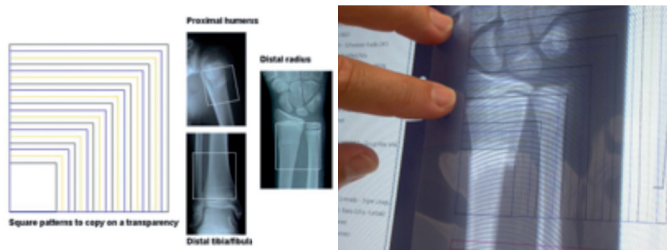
Use of the square patterns to classify a fracture as epiphyseal (E), metaphyseal (M) or diaphyseal (D). The square patterns are copied onto a transparency sheet and applied over the radiograph for more reliable and accurate diagnosis.
